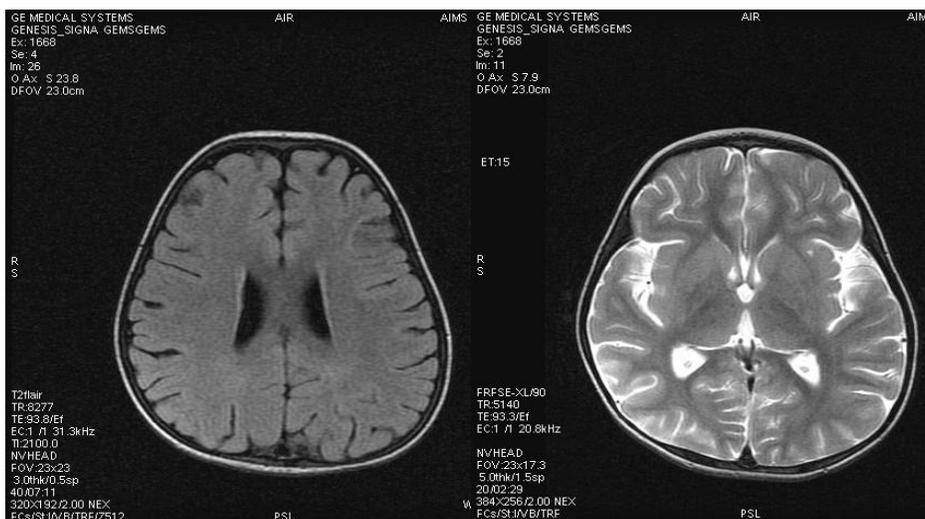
The previous lesions of the first scan had disappeared and appearance of ill defined T2 & FLAIR hyperintensities in right cerebellar hemisphere.
